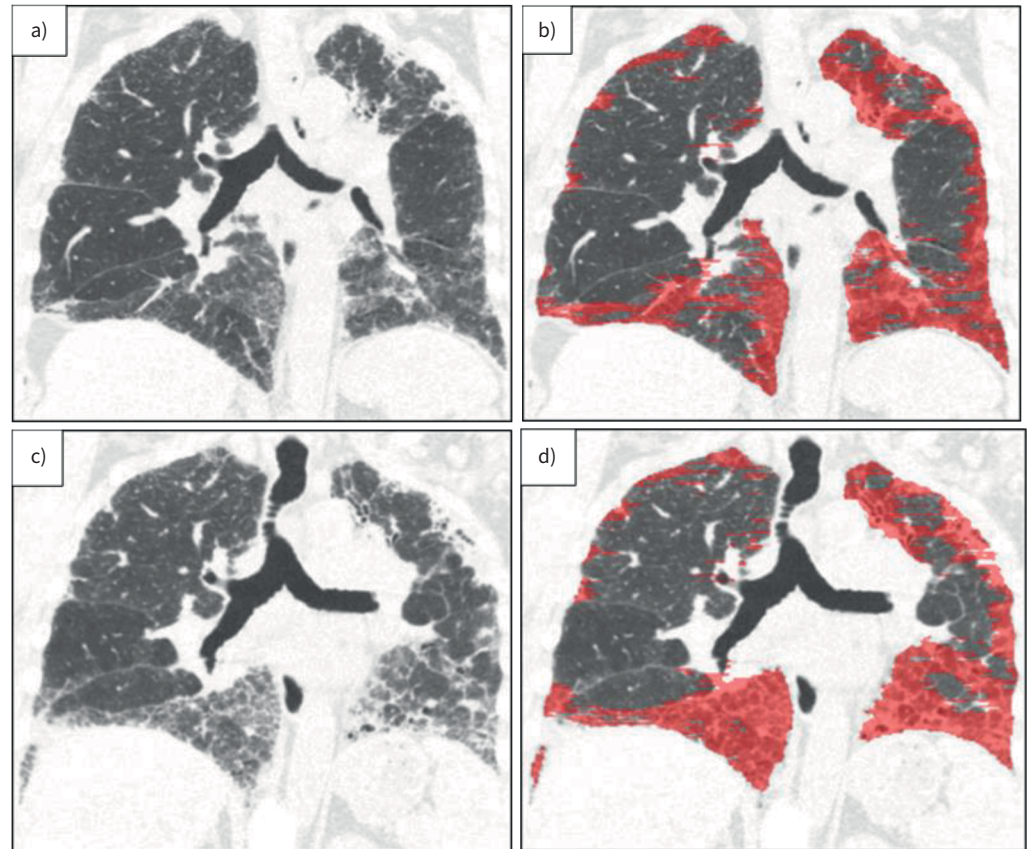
Data-driven texture analysis (DTA). Coronal computed tomography (CT) sections on a 66-year-old female with idiopathic pulmonary fibrosis. a) Visual CT pattern was indeterminate for usual interstitial pneumonia. Baseline CT with b) DTA classification as red overlay. DTA score (calculated as percentage of lung volume classified as fibrosis) was 33.0 at baseline. c) Follow-up CT at 1 year and d) DTA classification as red overlay. DTA score increased to 39.0 at 1 year follow-up. Courtesy of Stephen M. Humphries (National Jewish Health, Denver, CO, USA).
